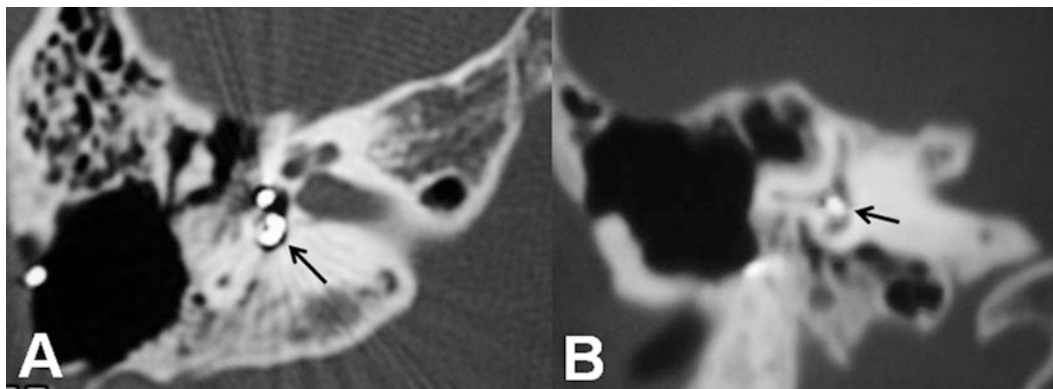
(a) Axial computed tomography demonstrating an electrode array in the vestibule (*arrow*). (b) Coronal computed tomography showing the electrode array in the vestibule (*arrow*)
